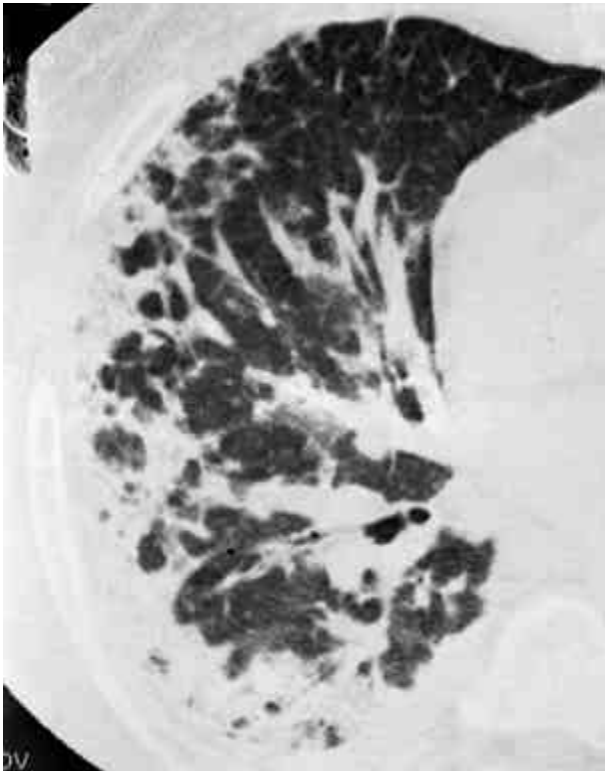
High-resolution CT of a 62-year-old woman with polymyositis shows predominantly consolidation which is located mainly peripherally.
